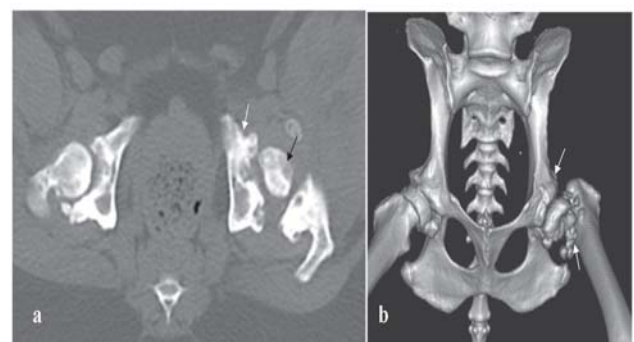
Reformatted CT image showing osteonecrosis of the femoral head and acetabulum (black arrow), fractured femoral head, and subchondral sclerosis with irregular acetabular margins (white arrow) in the transverse image (a); osteoproliferation at the left femoral head and neck (arrow), femoral head flattening with loss of joint space, and irregular broken displaced head in the 3D image (b).
